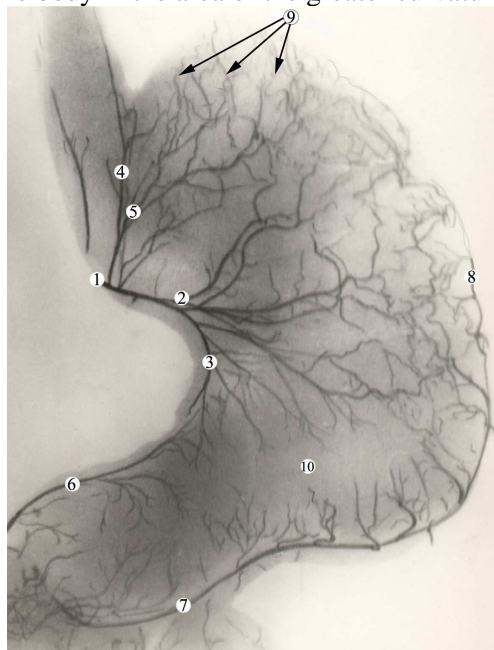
Roentgenogram of the arterial vessels of the stomach in the fetus, having 325 mm of crown-rump length. 1 – left gastric artery; 2 – anterior branch of the left gastric artery; 3 – posterior branch of the left gastric artery; 4 – branch to the esophagus; 5 – branches to the cardiac region; 6 – right gastric artery; 7 – right gastroepiploic artery; 8 – left gastroepiploic artery; 9 – short gastric arteries; 10 – low-vessel area of the body of the stomach.
